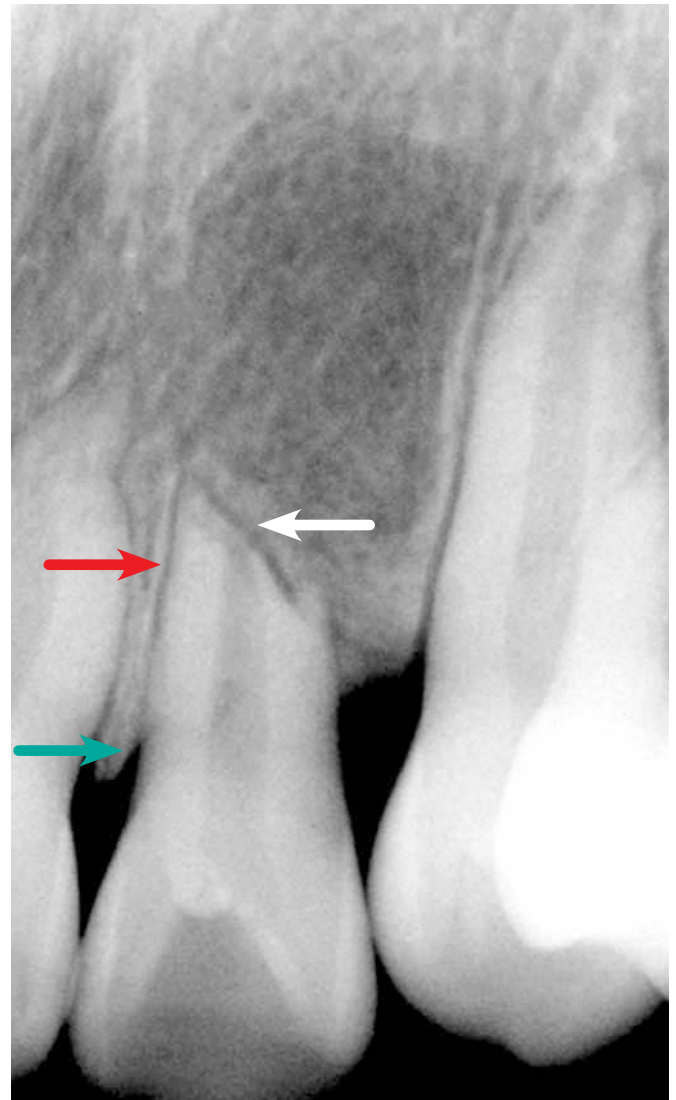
Apical inflammatory root resorption associated with occlusal trauma with thickening of the lamina dura (white arrow), widening of the periodontal space (red arrow) with increased periapical periodontal bone density (blue arrow), and V-shaped vertical bone loss (green arrow).
